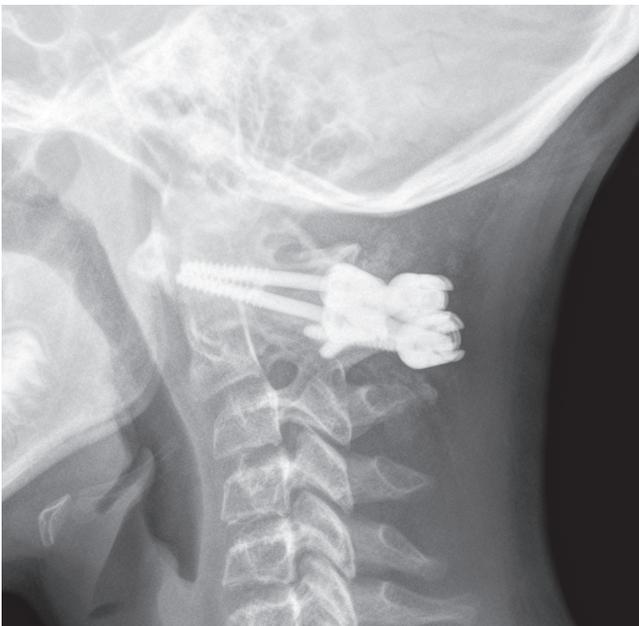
Postsurgery radiograph shows posterior C1, C2 instrumentation and fusion with C1 lateral mass screws and C2 laminar screws.
